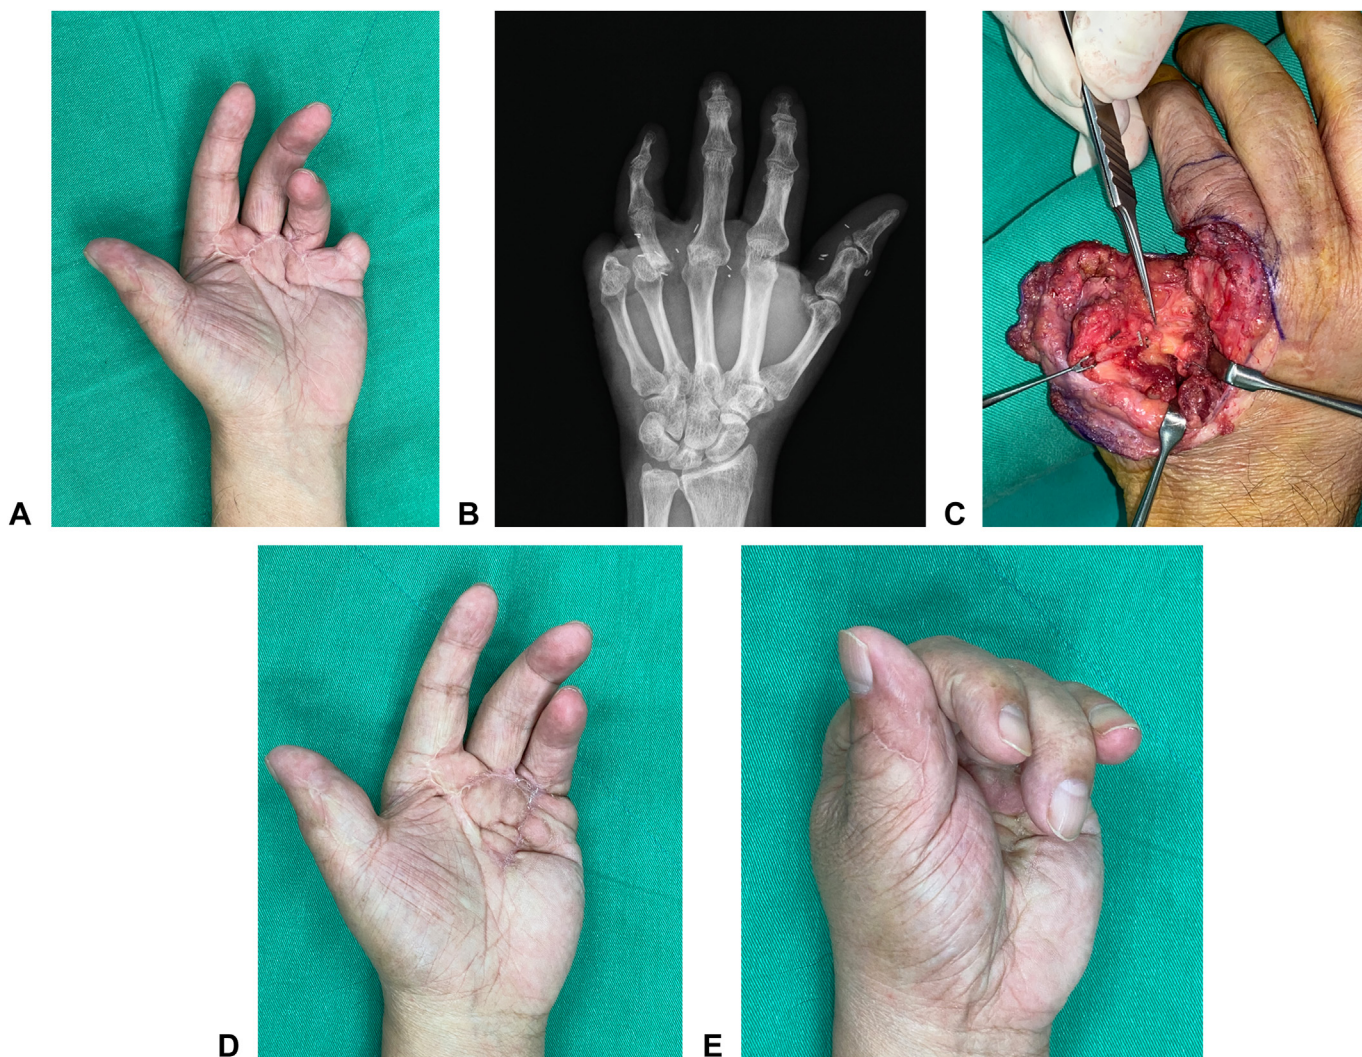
A Severe flexion contracture and malrotation of the ring finger and a short amputation stump of the little finger. B The X-ray revealed absence of the fourth MCP joint, but the fifth MCP joint remained intact. C The tip of microvascular forceps indicated the vessel supplying the spare MCP joint flap. Transferring the intact vascularized fifth MCP joint to replace the missing fourth MCP joint. D, E Improved function and appearance of the left hand.
